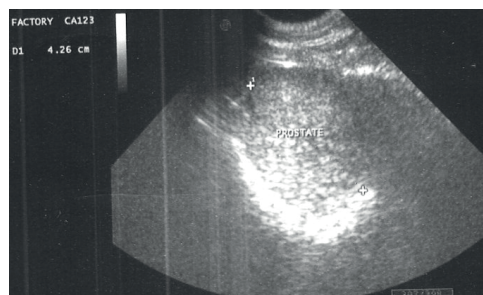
Ultrasound of a patient with a large paraprostatic cyst (FMVB)
